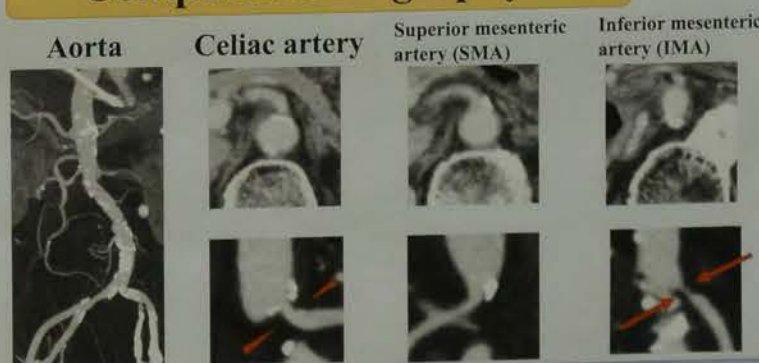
CT (CE). Mild stenosis of the celiac artery (arrowheads) and severe stenosis of the inferior mesenteric artery (arrows).
